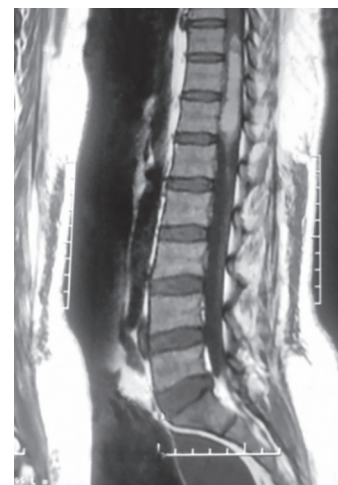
T1-weighted MRI sagittal image
